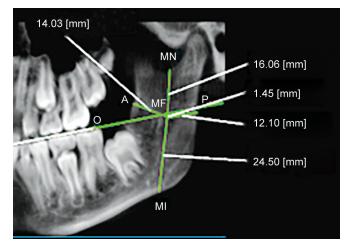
Assessment of MF using CBCT: landmarks used in the present study
